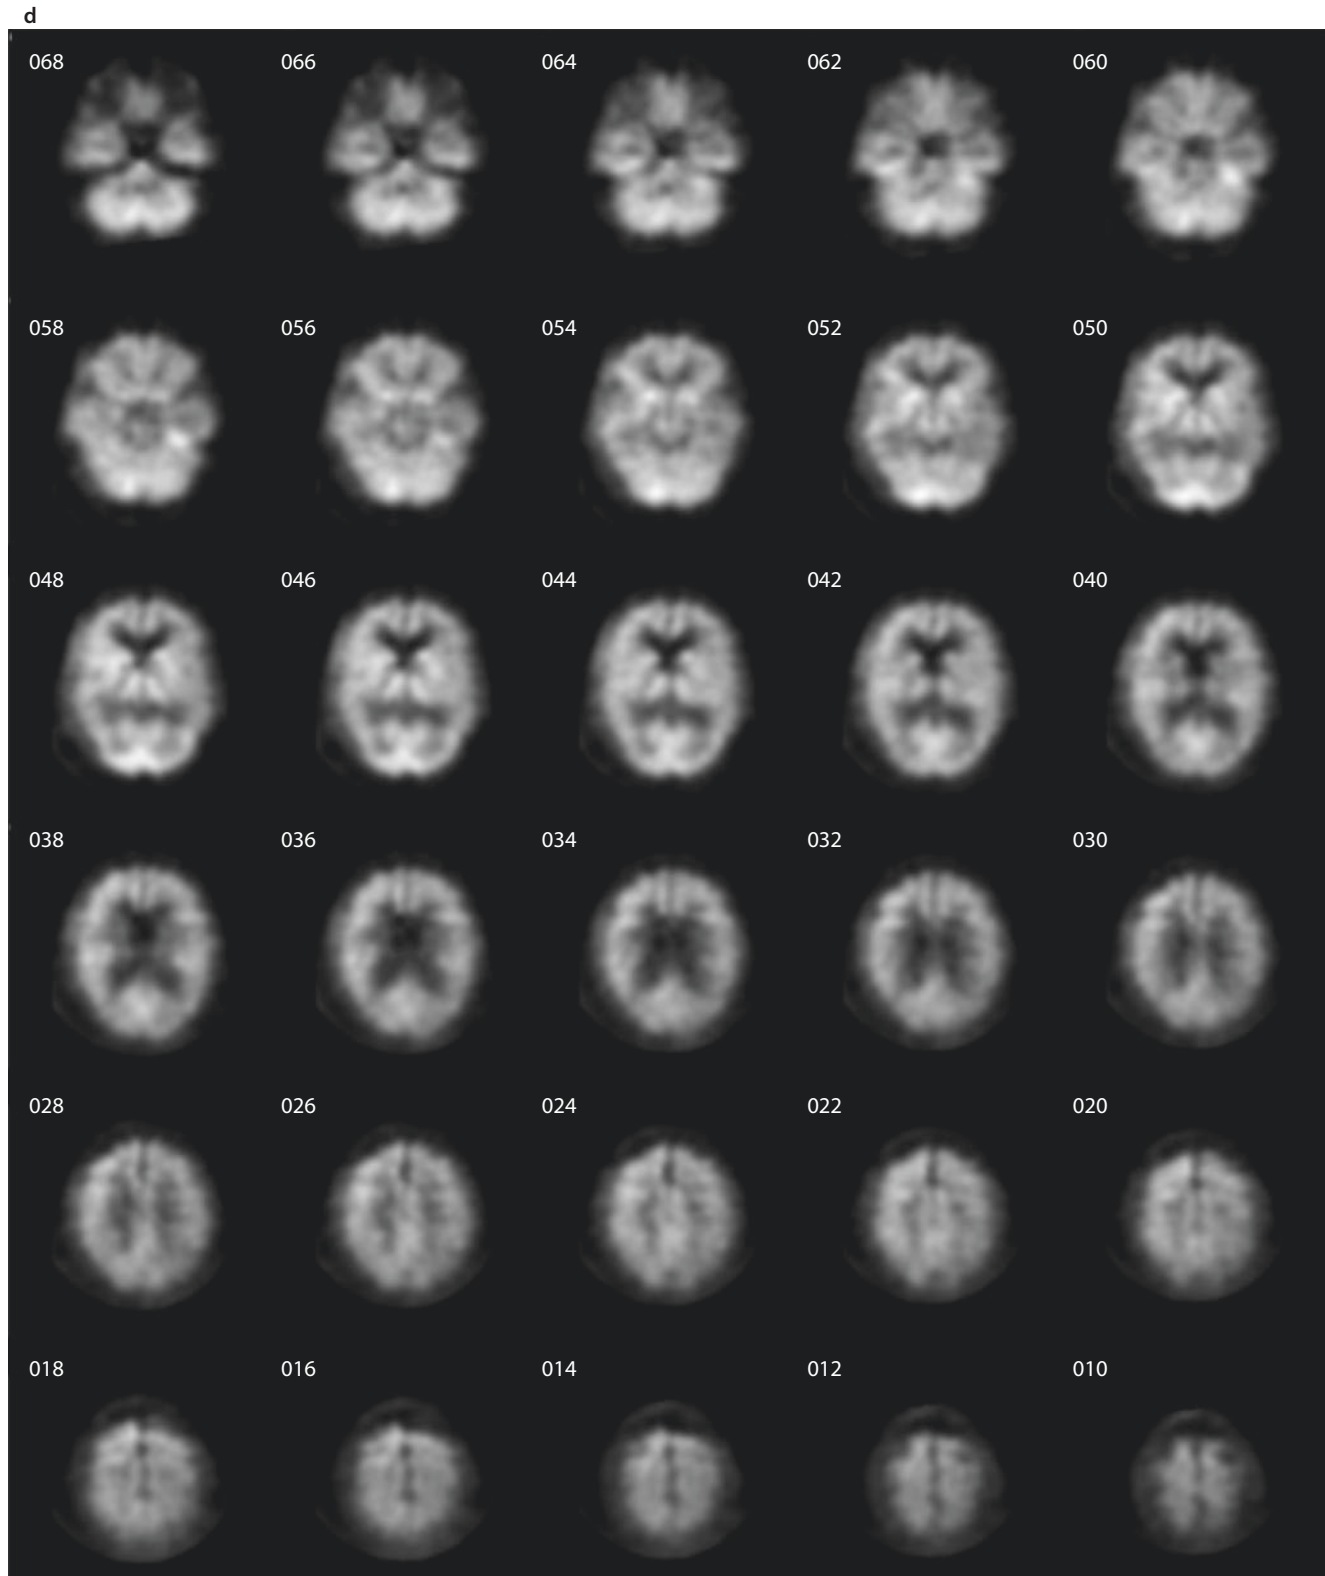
(continued) c Standard PET 18F-FDG cerebral study
